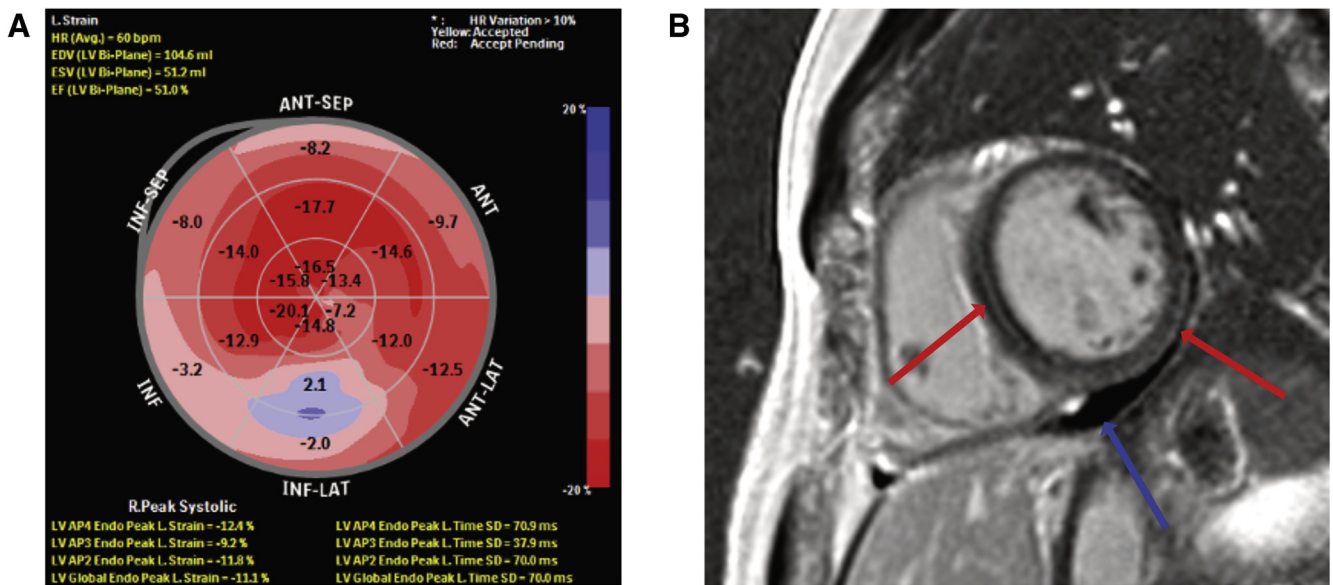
A: Pathologic strain analysis, predominantly inferolateral. B: Cardiac magnetic resonance imaging shows pathologic late gadolinium enhancement (red arrows) and pericardial effusion (blue arrow).
